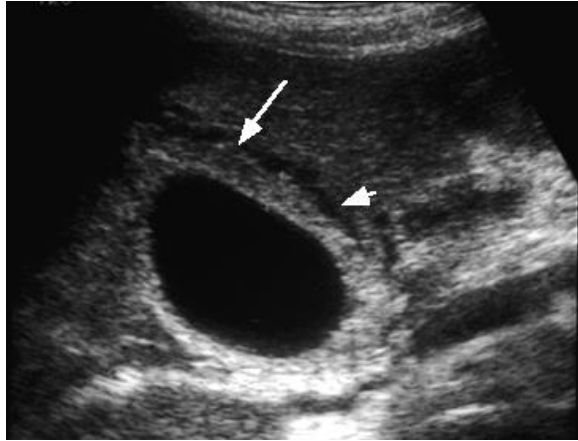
Acute cholecystitis Ultrasound of the right upper quadrant in a patient with acute cholecystitis reveals marked thickening of the gallbladder wall (arrow) with fluid surrounding the distended gallbladder (arrowhead).
